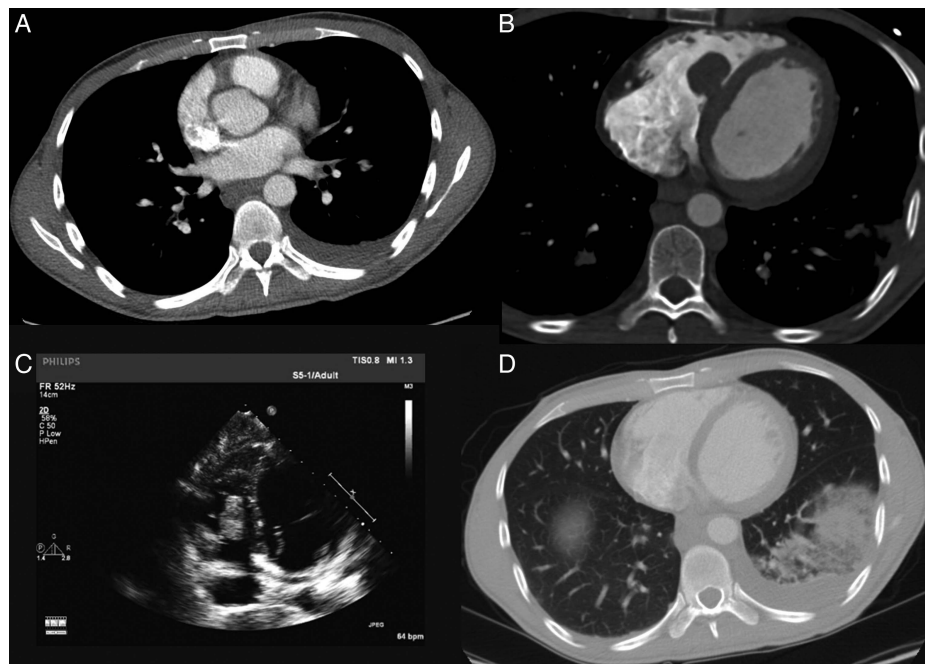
(A) Bilateral pulmonary embolism and left-sided pleural fluid. (B) Mass in the right ventricle (RV) seen by CT of the thorax. (C) Mass in the RV seen by transthoracic echocardiography. (D) Decreased mass in the RV and lung infarction.
